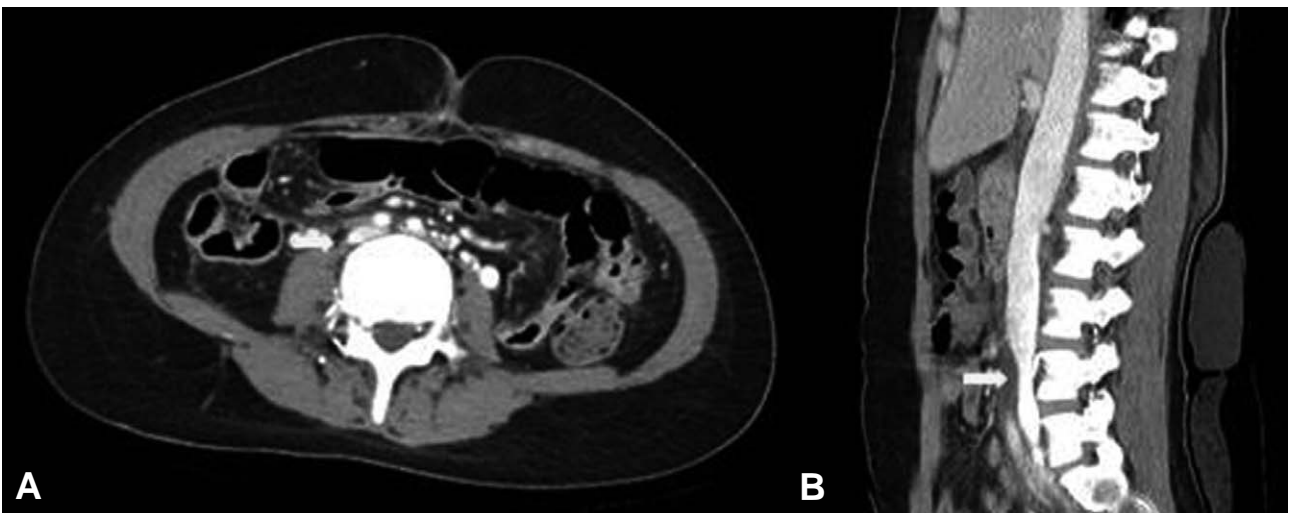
In follow-up CT scan 1 month after operation, focal stenosis without flow-limitation was identified and there was no deep vein thrombosis of venous system. (A) Axial view (B) Sagittal view
